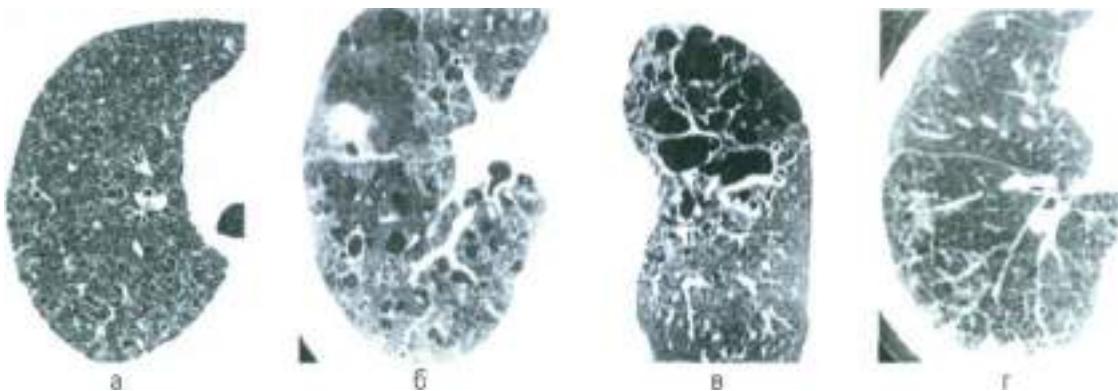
CT variants of histiocytosis. Diffuse centrilobular nodules and microcystic changes (a). Multiple predominantly small cysts, some confluent, communicating with isolated subpleural nodules; the intervening parenchyma demonstrates ground-glass attenuation (b). Large confluent cysts, predominantly in the upper lobes (c). Progressive involvement of the lung parenchyma leading to widespread fibrotic changes (d).
